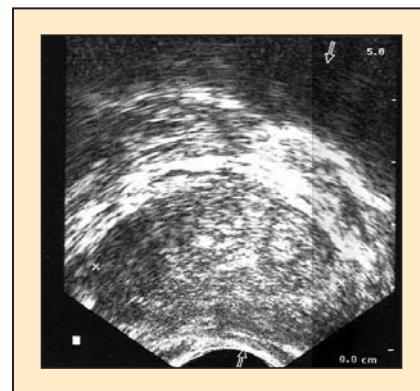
A staging ultrasound in a patient presenting with a question of locally advanced prostate cancer. The patient is a 63-year-old male with serum prostate-specific antigen (PSA) of 8.2, a palpable nodule in the left prostate, and Gleason 3+4 disease in multiple biopsy cores. Transrectal ultrasound (TRUS) demonstrates cancer extending to the prostate capsule, but no clear extraprostatic extension is seen. At surgical resection, the patient was confirmed to have extracapsular disease.
